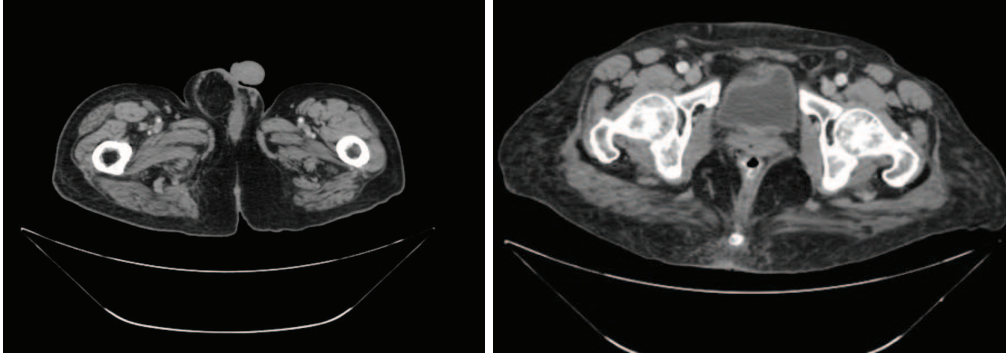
Left - A slice in a CT scan of a femur shaft. Right - CT scan of femoral head. The femoral head and the pelvis seem to be connected.
